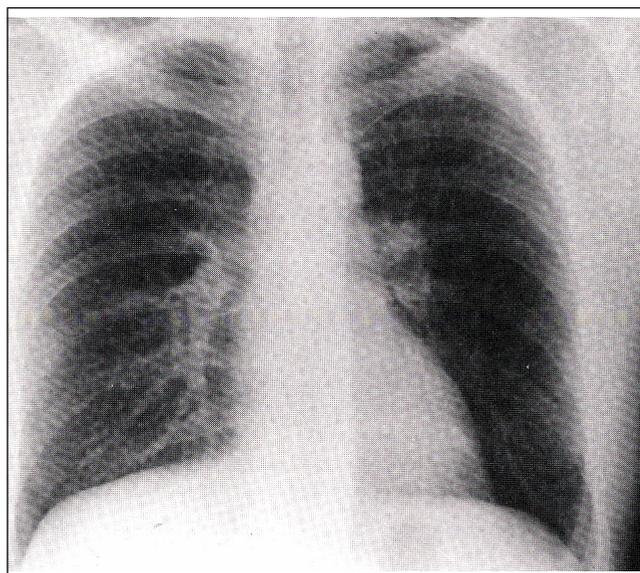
Anteroposterior chest radiograph of case 2. Note the diffuse increase in interstitial markings
